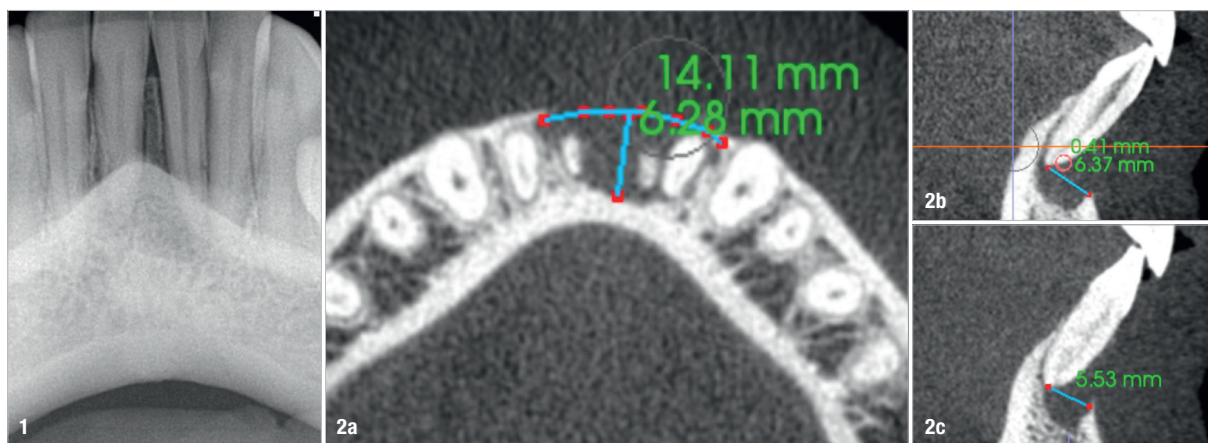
Pre-op radiograph of the patient. Figs. 2a–c: Horizontal view of the i-CAT scan showing a large bone defect (a). Vertical views of both central incisors showing the bone loss (b & c).
